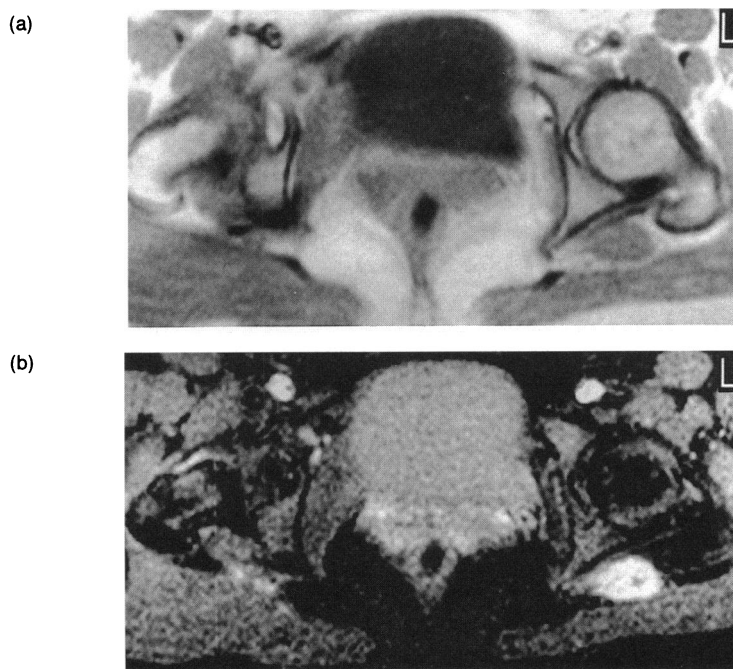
Axial T1-weighted FSE (a) and axial STIR (b) images of the pelvis showing a mass in the region of the sciatic nerve anterior to the wasted adjacent gluteal muscles of the left buttock. The lesion appears predominantly low signal on T1, typical of soft tissue tumours, but is much more conspicuous on STIR due to suppression of the signal from adjacent fat.
